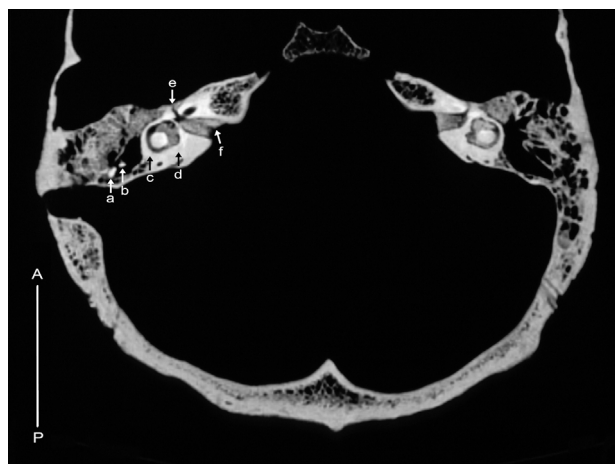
Axial CT scan of both ME cavities and antra at the level of visible inner auditory meatus and facial nerve canal. Incus (a) and caput mallei (b) in the right antrum, horizontal semicircular canal (c), otic capsule (d) labyrinthal part of the facial nerve canal (e), inner auditory meatus filled with the sediment matrix (f).
